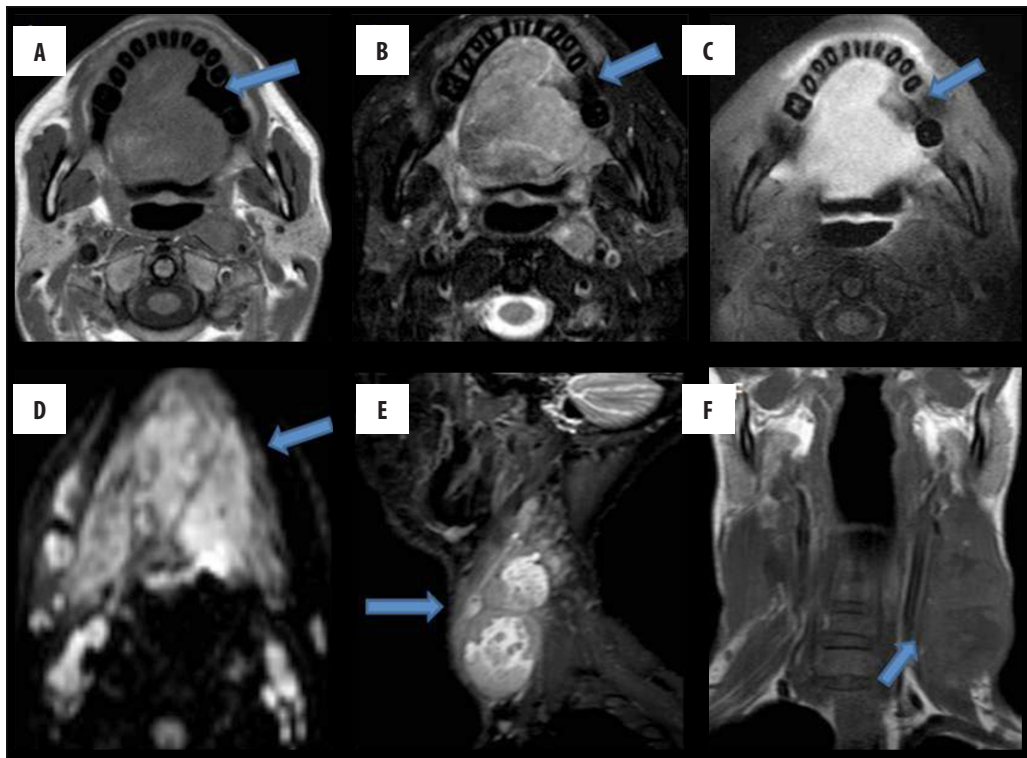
Shows a lesion with ill-defined soft tissue signal intensity, involving almost the whole tongue, appearing isointense on T1W (A), heterogeneously hyperintense on T2W images (B), showing moderate contrast enhancement (C). On DWI, it shows restriction (D). Posteriorly, it involves the base of the tongue and obliterates the oropharyngeal lumen. Multiple heterogeneously-enhancing lymph node masses seen along both jugular chains (E, F).
